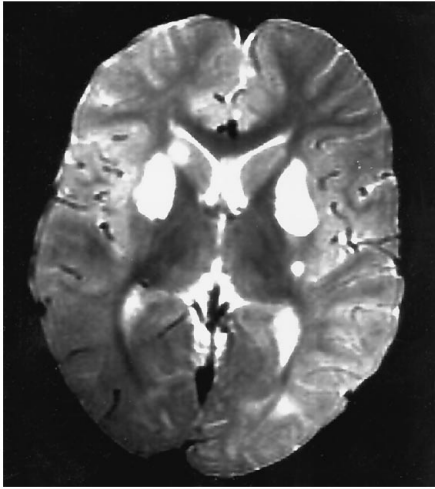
An 8-year-old boy with a 3-month history of SSPE, clinical stage G:IIIB. T2-weighted (2000/80/2) MR image at admission shows extensive high-intensity lesions in lentiform nuclei bilaterally and in right caudate head, and minimal subcortical white matter lesions (MR stage 1). A repeat MR study (not shown) after 7 months showed atrophy and high T2 intensity of lentiform nuclei and caudate heads but was otherwise unchanged.
